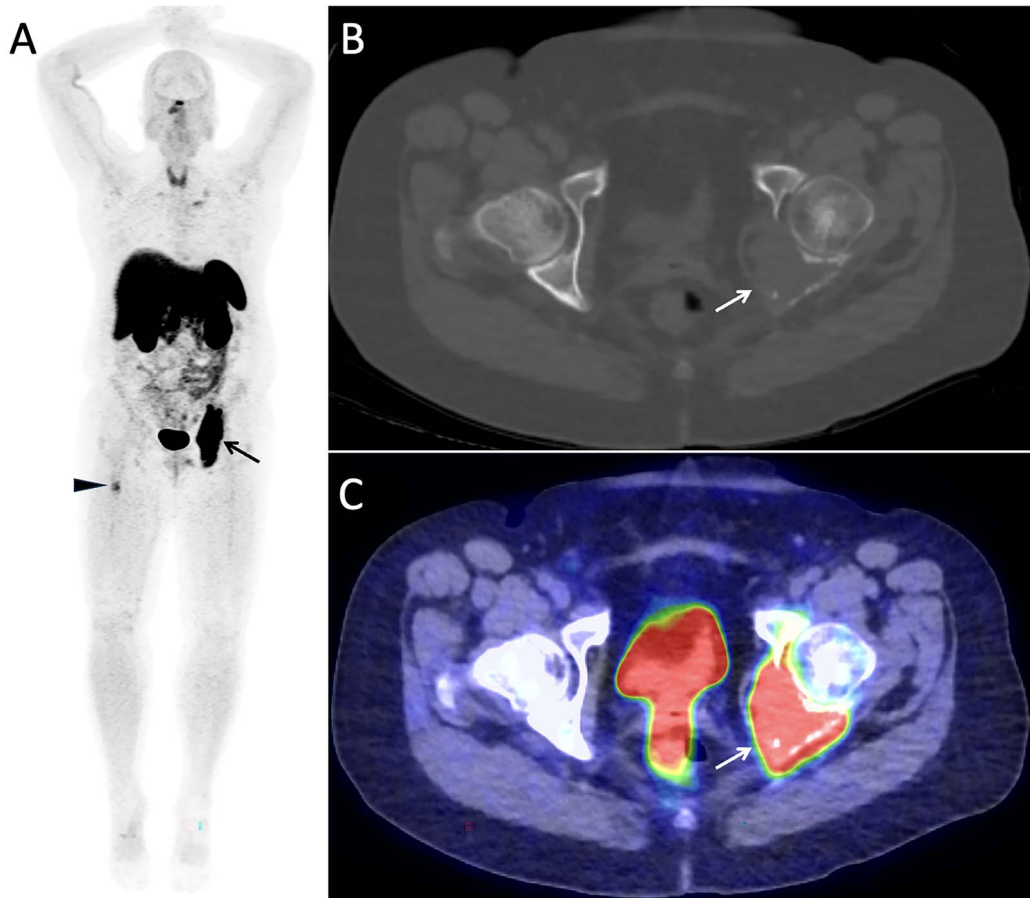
Maximum intensity projection PET (A), axial CT (B), and fused PET/CT (C) images from a Ga-68-DOTATATE PET/CT examination demonstrate intense uptake within a large destructive lytic PMT involving the posterior left acetabulum and left ilium (arrows) (Subject 19). There is also focal uptake within a proximal right femoral insufficiency fracture (A, arrowhead).
